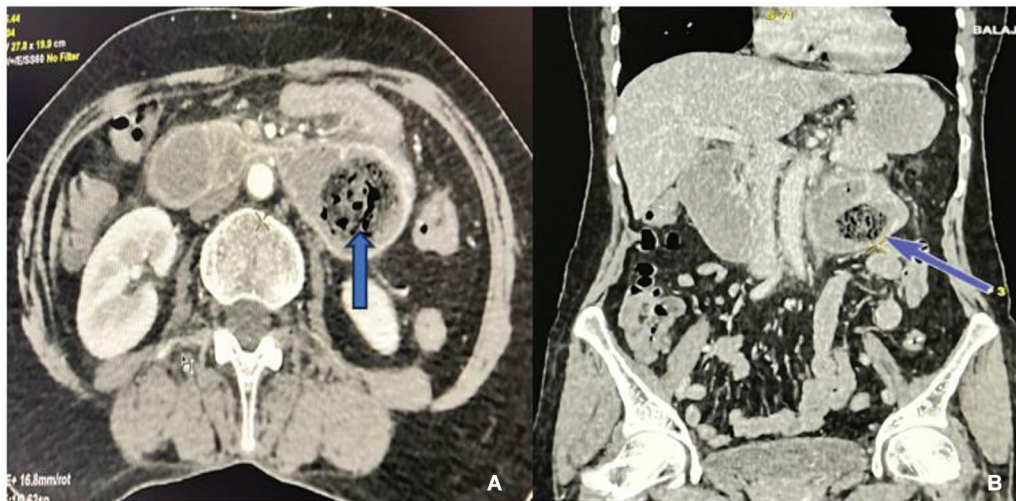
(A, B) Computed tomography showing the intraluminal round bezoar and mottled gas pattern were seen in the duodenal segment. Wall thickening due to inflammation was seen at the obstruction site (arrow).
